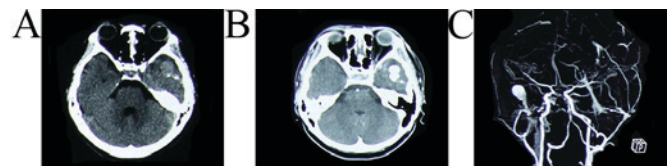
(A) CT scan performed on day 38 post-head injury revealing a hyperdense nodule in the left temporal parenchyma. (B) On contrast-enhanced CT, the hyperdense lesion displayed as an intense, homogeneous enhancement. (C) Three-dimensional CT angiogram indicating a pseudoaneurysm of the left external carotid artery branch. CT, computed tomography.
